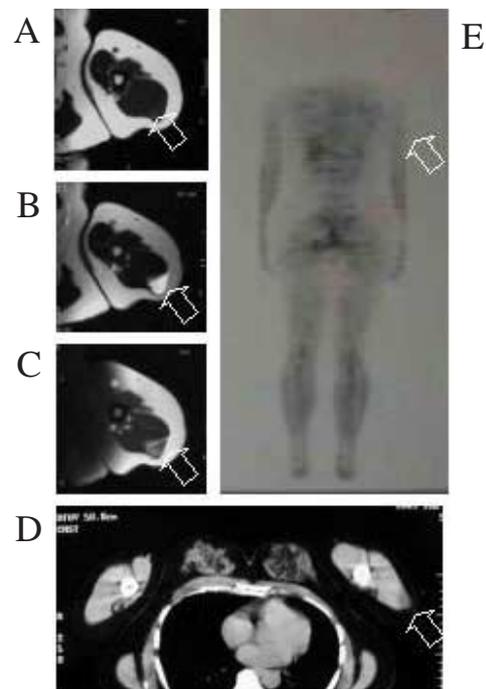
An intramuscular myxoid type of liposarcoma that developed in the left arm in a 48-year-old female (patient number, 43). T1-weighted images (A) show an intramuscular low-signal lesion with fine gadolinium enhancement (C). T2-weighted images reveal a homogeneous lesion with high signals (B). CT demonstrates a homogeneous lesion with mild density (D). Neither septa nor nodular features were found in either MR images or CT scan. Whole body scan of FDG-PET reveals a mildly increased uptake with SUV of 0.79 localized in left arm.
